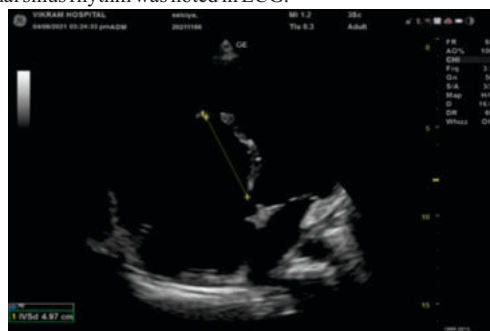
Two dimensional echocardiography showing ebstein anomaly
